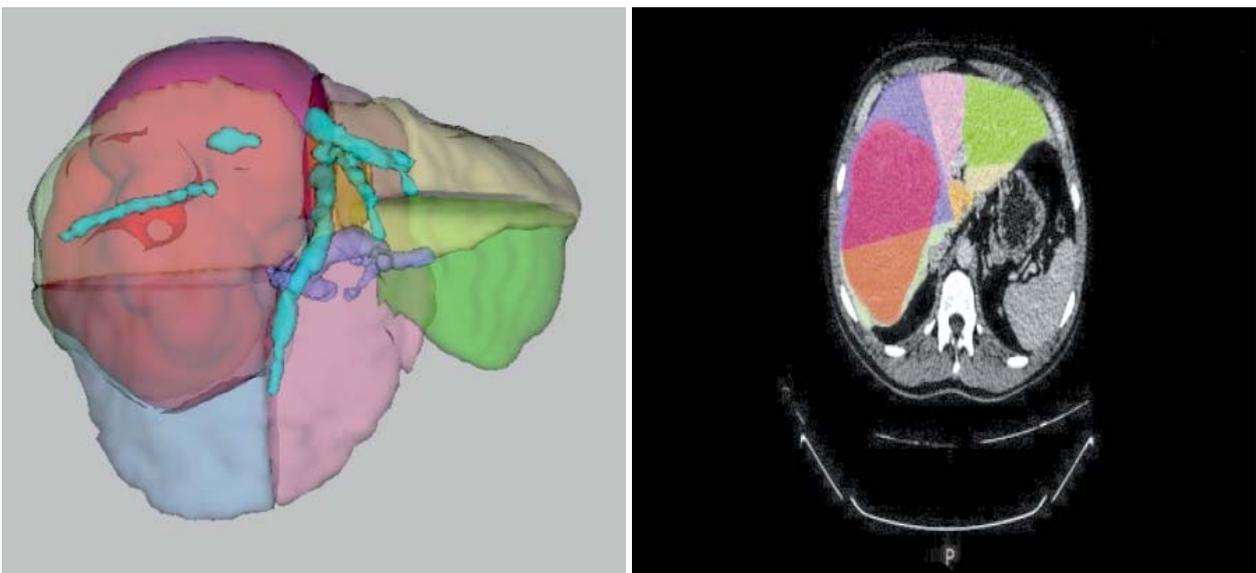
CT volumetry and liver segmentation
